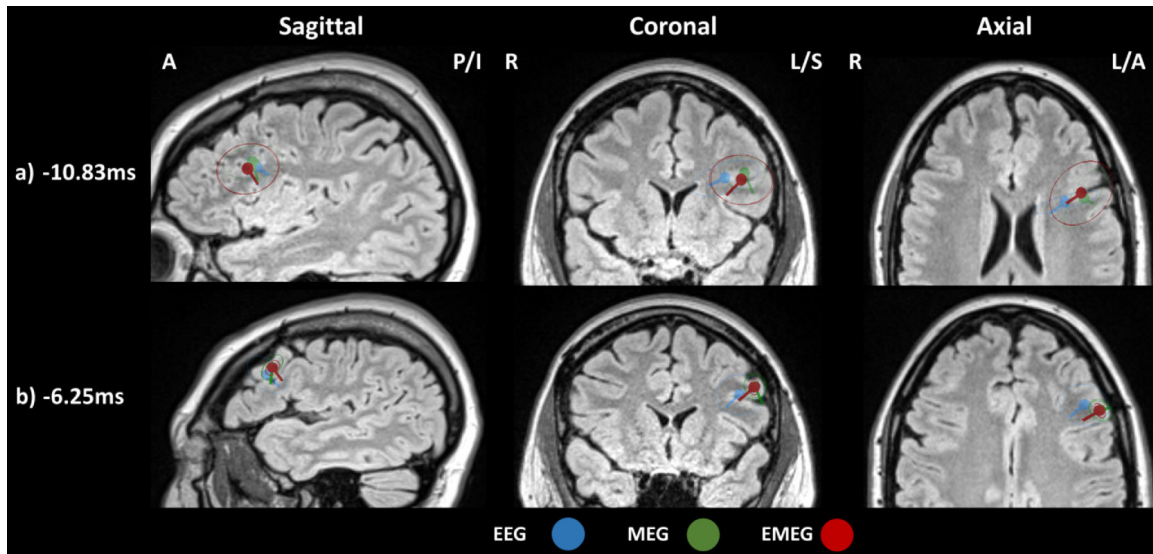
Measurement modality source reconstruction comparisons: Spike cluster centroids and spread ellipsoids are depicted on the FLAIR MRI views (sagittal (left column), coronal (middle column) and axial (right column)) at a) -10.83 ms and b) -6.25 ms. The centroid dipoles are presented for each modality (EEG: blue, MEG: green and EMEG: red) when the most detailed head model was used 6CAH_Cal. The MRI slices are presented for the position of the EMEG centroid dipoles. The size of all dipoles is kept constant. Anterior (A), Posterior (P), Inferior (I), Left (L) and Right (R) shows MRI orientation.
